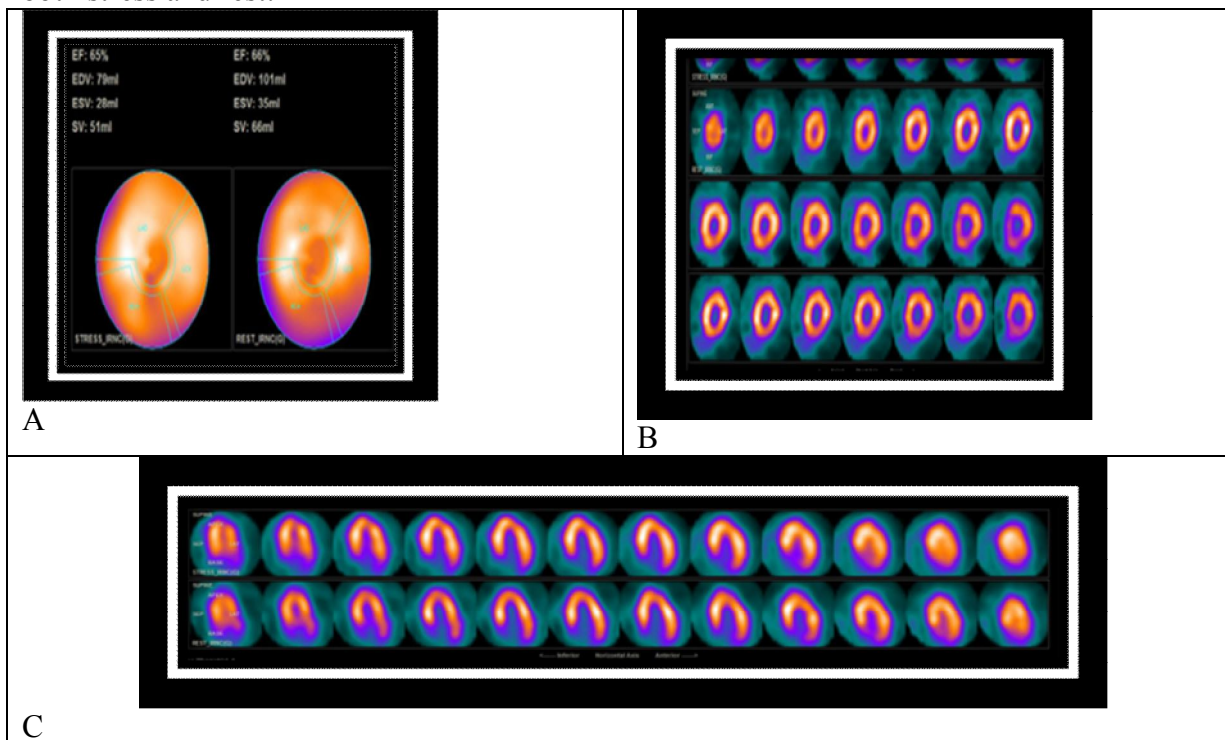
A male patient was complaining of atypical epigastric pain. A: SPECT polar map shows LV functional parameters. B: Normal perfusion of SPECT MPI short axis view at both stress and rest. C: Normal perfusion of SPECT MPI vertical axis view at both stress and rest
